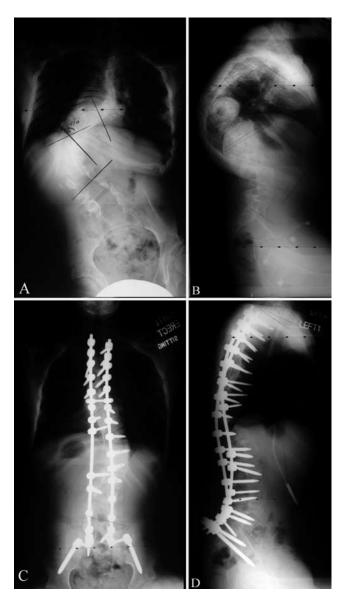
Preoperative posteroanterior (A) and lateral (B) full spine radiographs obtained in a 15-year-old boy with an L-2 level myelomeningocele, showing a > 100° scoliosis curvature. The boy underwent a T-2 to pelvis posterior spine fusion without a prior untethering procedure. Postoperative posteroanterior (C) and lateral (D) radiographs showing good correction.
